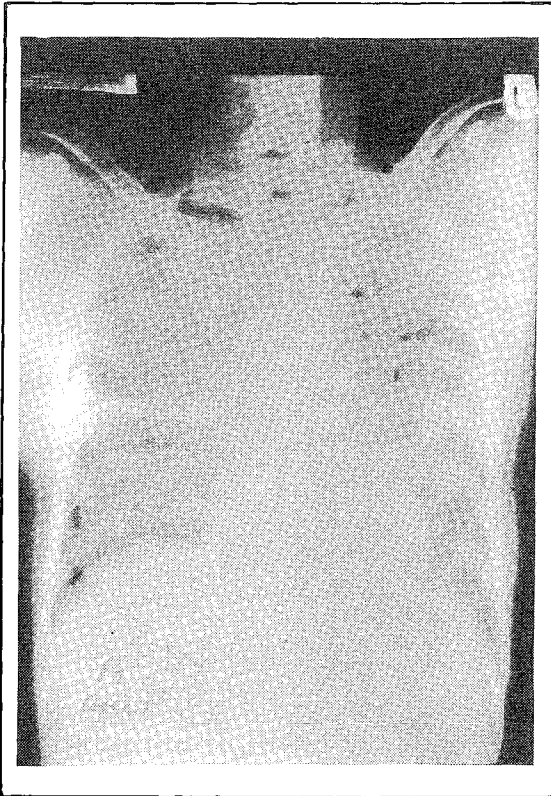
Chest X-ray showing widespread soft opacities in both lung fields.
